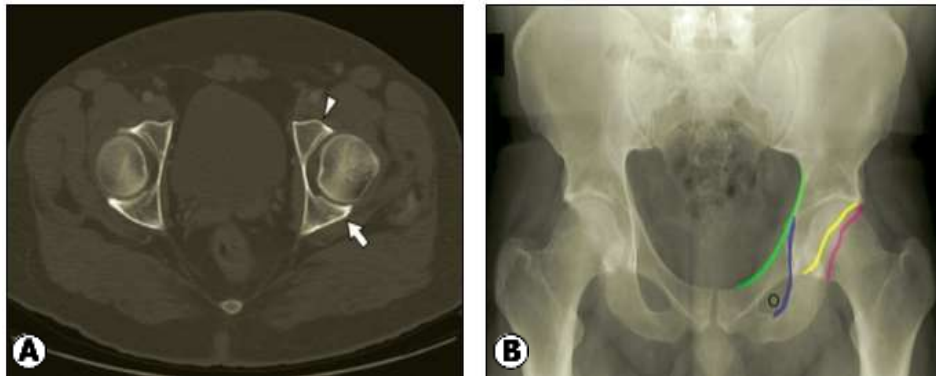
A-Axial section through acetabulum shows anterior (arrowhead) and posterior (arrow) walls. B-Anteroposterior radiograph shows iliopectineal line (green), ilioischial line (blue), anterior acetabular wall (yellow), posterior acetabular wall (pink), and obturator foramen (O) ^[7].
